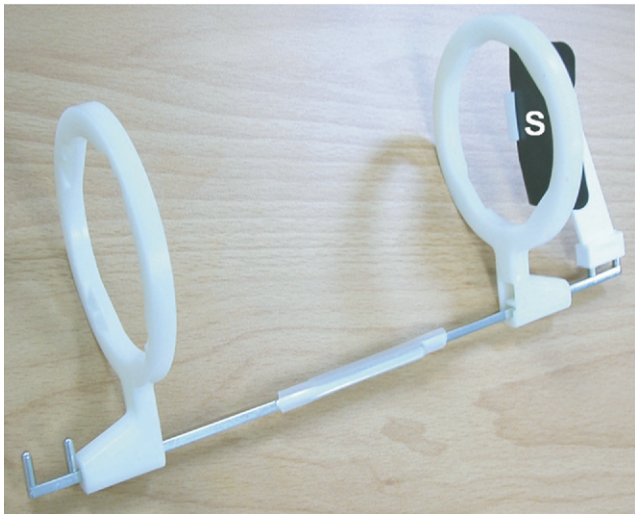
The finished aiming device with placement of the sensor. Note that the exposing surface (S) of the sensor should be oriented in the direction of the X-ray cone.
